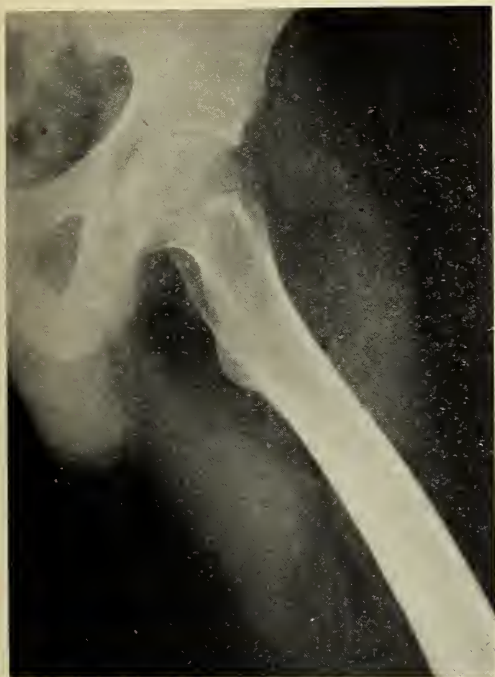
(Case 2). Roentgenogram of a large lipoma surrounding the upper end of the femur adjacent to the joint capsule.
